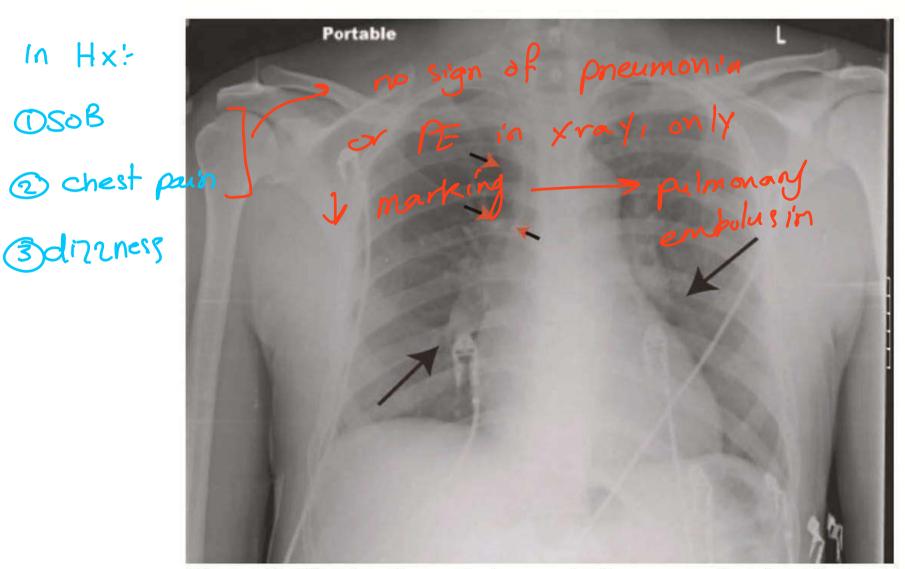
Chest radiograph demonstrating a prominent central pulmonary artery (early Fleishner's Sign, red arrows) and a cut-off of the pulmonary arteries bilaterally (Westermark sign, black arrows).
